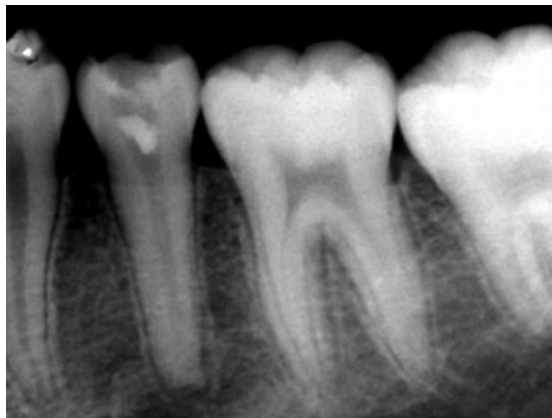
Preoperative radiograph of the mandibular left premolar (35). Note the wide-open apex and periapical radiolucent lesion.
